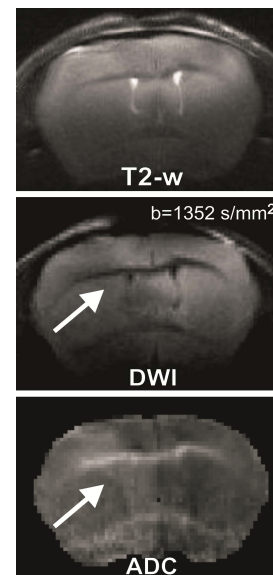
T2-w and DWI images, and ADC map from LN-2669GS glioma sphere xenograft. Lesion indicated by arrow.
